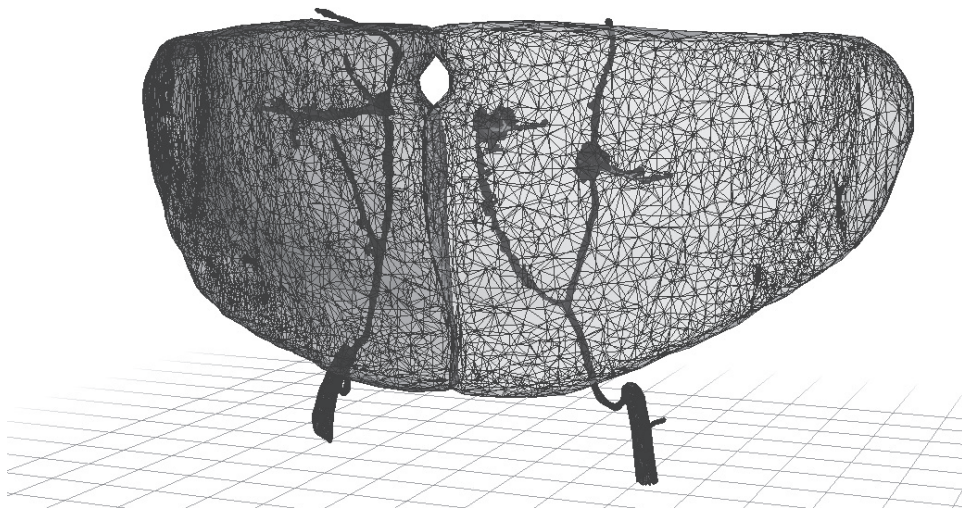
3D planned DIEP flap for a bilateral breast reconstruction without lymph node transplantation based on CTA. The 3D reconstruction indicates the total flap size and relevant blood vessels.
